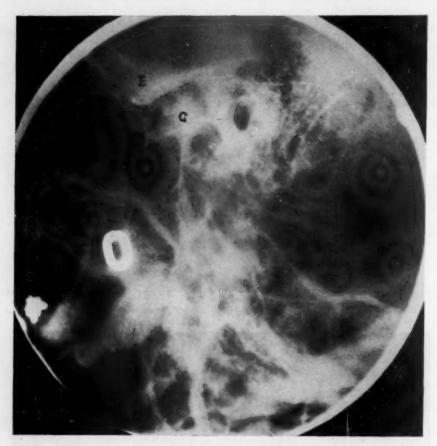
X-ray of temporomandibular joint showing ankylosis of the condyle, C; E, eminentia articularis.
